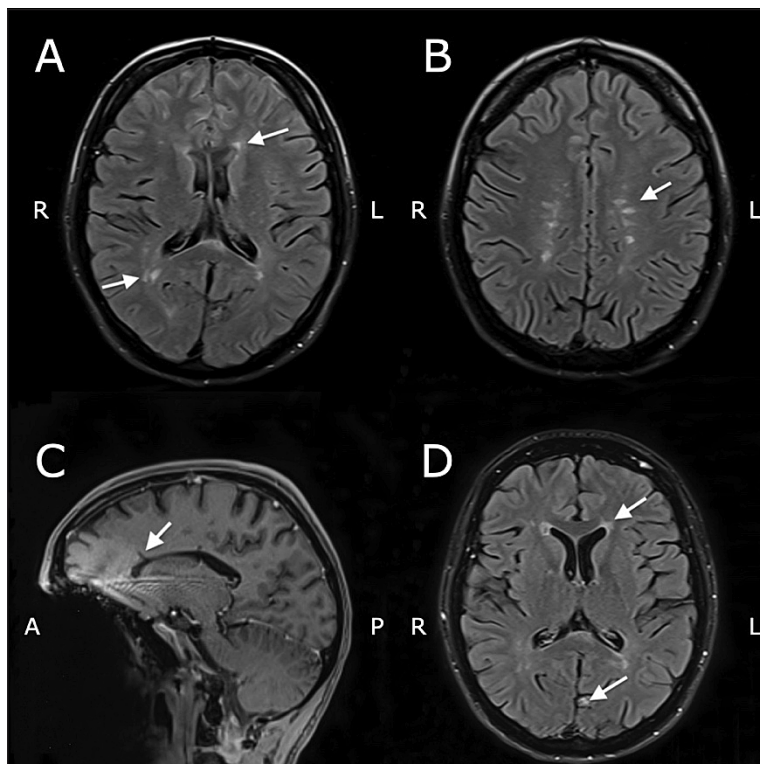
Brain MRI (performed in 2017 and 2018).
